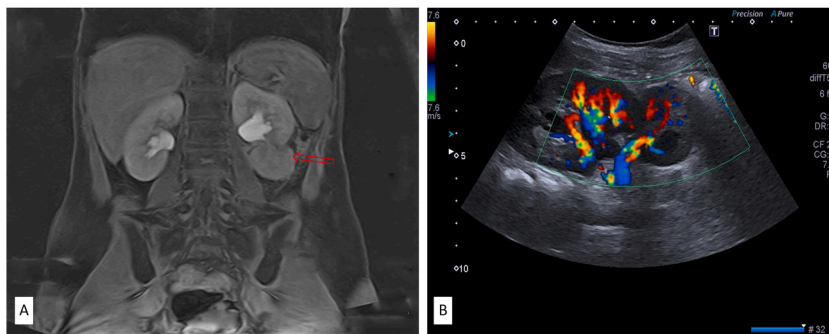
A–B: (A): MRI urography was done with a post-contrast MR image showing mild hypoperfusion of the lower pole of the left kidney (red arrow); (B): A subsequent color Doppler ultrasonography confirmed the MRI urography findings. (For interpretation of the references to color in this figure legend, the reader is referred to the Web version of this article.)
